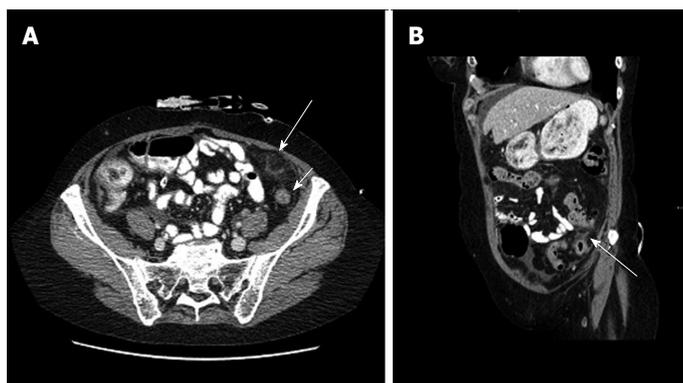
Computed tomography. A: Axial computed tomography (CT) scan of the abdomen showing a fat density area with some surrounding inflammation (large arrow) anterior to the descending colon (small arrow) in the left iliac fossa just below the abdominal wall at the site of epiploic appendagitis; B: A coronal oblique CT image showing the fat density area with surrounding inflammation (arrow) adjacent to the descending colon.
